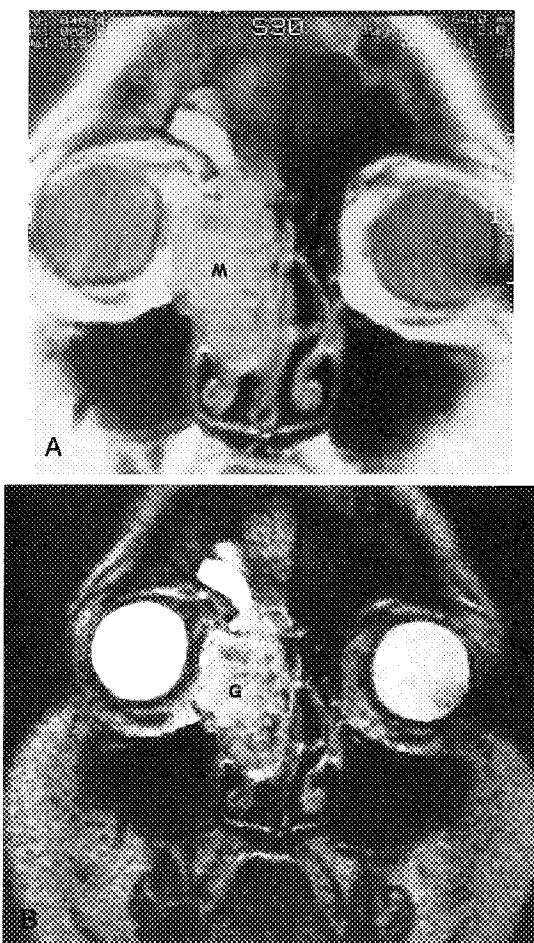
Giant cell tumor. A, Proton-weighted MR scan shows a soft tissue mass (M) involving right ethmoid and nasal cavity, invading the orbit, and compatible with the giant cell tumor. B, T2-weighted MR scan. The giant cell tumor (G) appears hyperintense.
